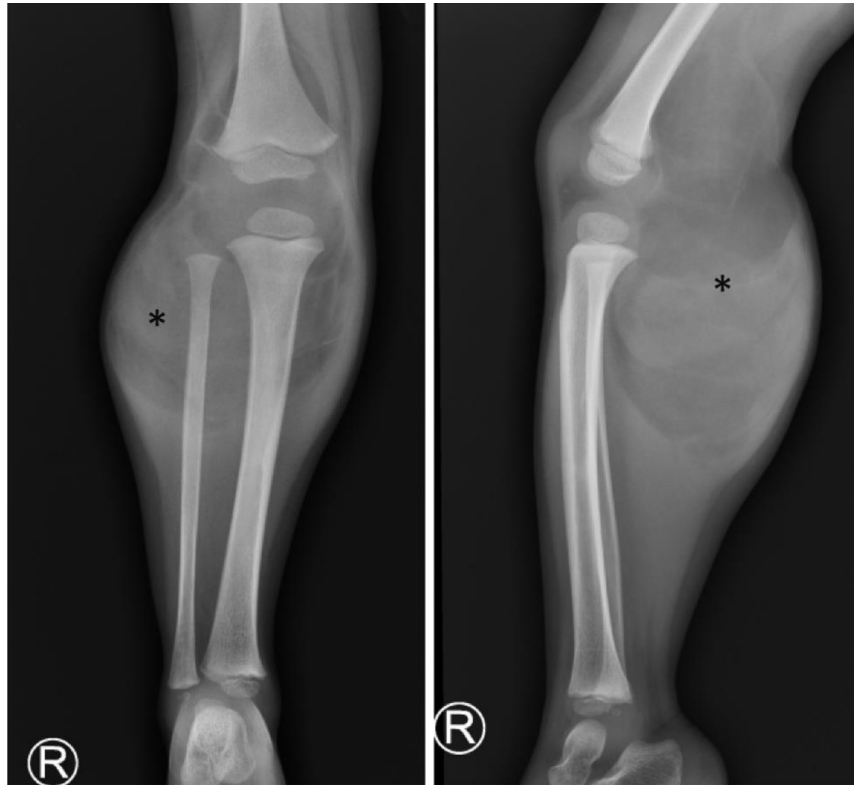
Plain radiography of the right cruris. The anteroposterior (left) and lateral (right) images showed the presence of a heterogenous soft tissue mass (asterisk) without calcification in the right popliteal fossa extending to the proximal cruris.
